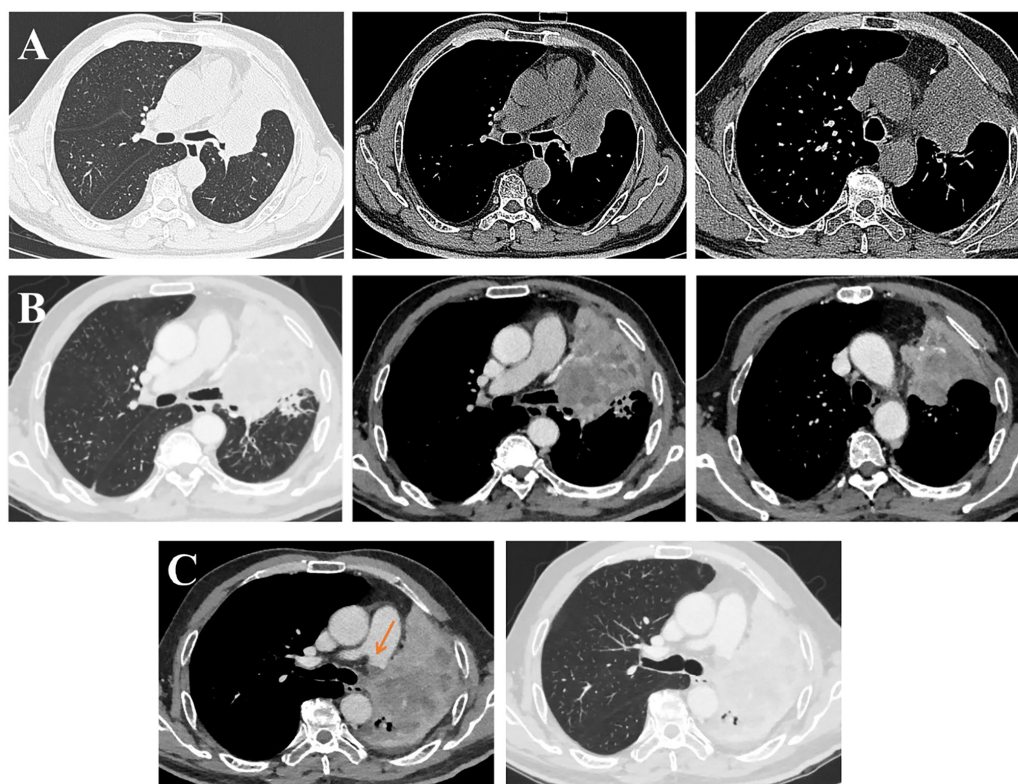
Chest computed tomography images of the patient during therapy. (A) Before therapy on September 27, 2020. (B) After the second cycle of neoadjuvant immunotherapy in combination with chemotherapy on December 8, 2020. (C) After the fifth cycle of chemotherapy on February 7, 2021. The orange arrow indicates the main trunk of the left pulmonary artery, which was completely invaded by the tumor. This demonstrated that the patient was unable to undergo surgery.
